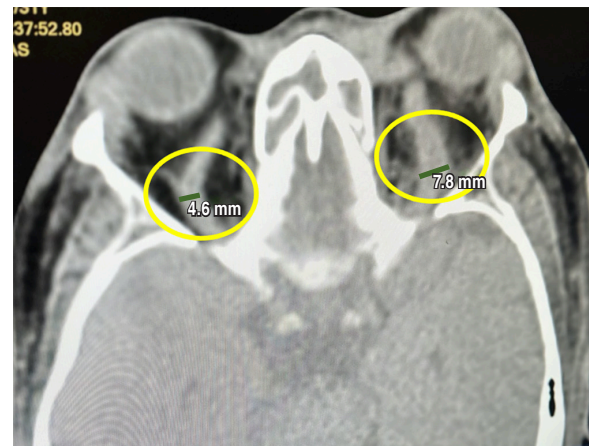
Computed tomography scan revealing bilateral superior ophthalmic vein thrombosis (yellow circles).
